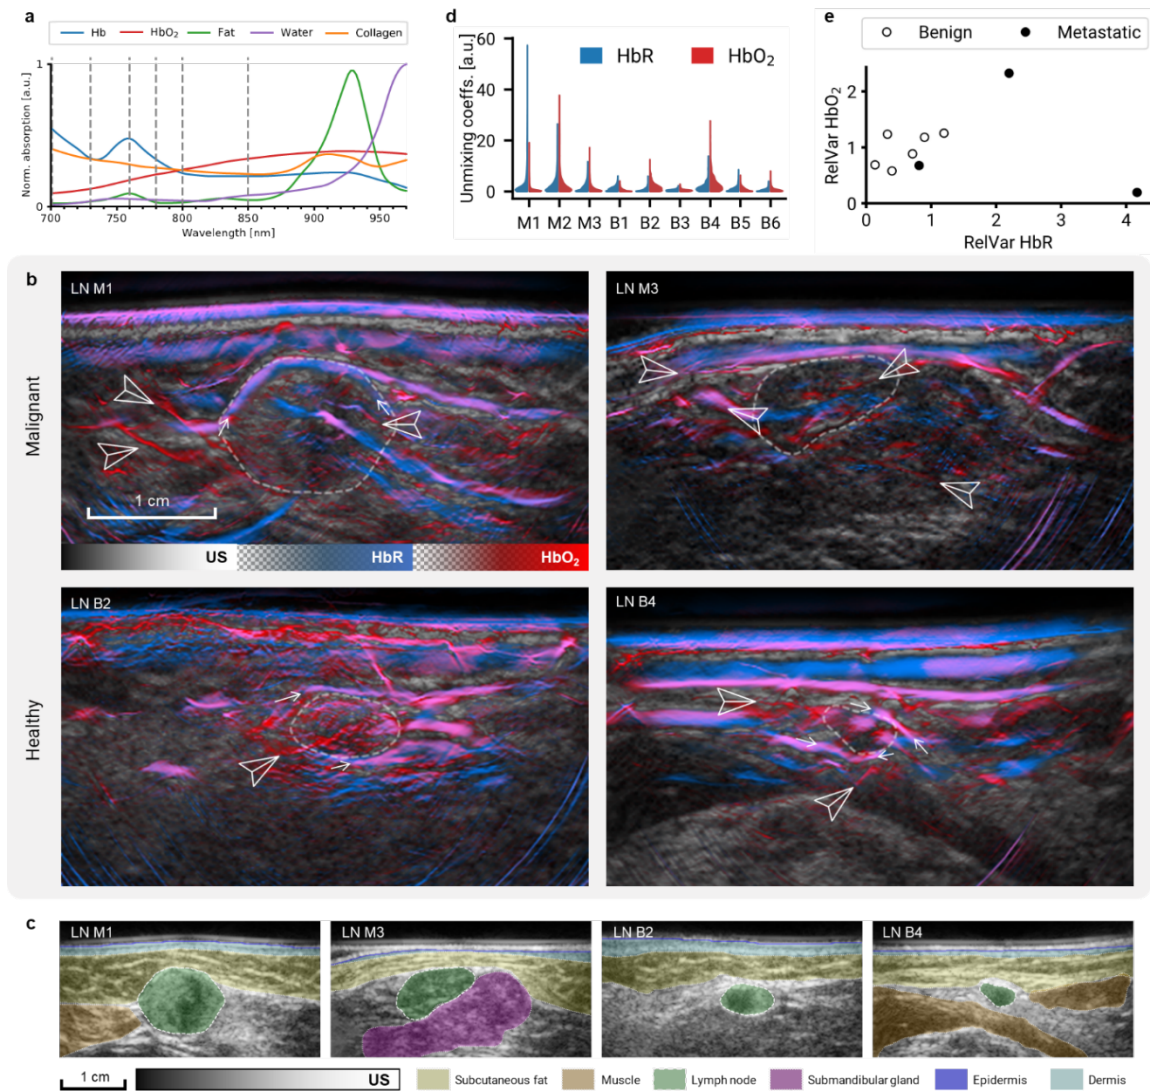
Intrinsic contrast in lymph nodes. a, Absorption spectra of main endogenous chromophores in the illumination range of the MSOT Acuity Echo scanner. Dashed lines denote the wavelengths used for the multispectral image acquisition (700, 730, 760, 780, 800, 850 nm). b, Ultrasound and linear spectral unmixing images of lymph nodes (LNs) M1, M3, B2, and B4. Arrowheads mark peripheral, feeding, and intranodal blood vessels. Small arrows mark signal enhancement around the LNs. Scalebar applies to all four images. Separate HbR and HbO₂ maps are provided in Fig. S4. Strong HbR signal in the epidermis can be attributed to the presence of melanin. c, Ultrasound images of the LNs displayed in (b) with localization of surrounding anatomical landmarks. d, Distribution of Hb and HbO₂ unmixing coefficients in three malignant LNs (M1-3) and six benign LNs (B1-6). e, Variance of chromophore concentrations in malignant and benign LNs relative to their 3 mm margins. Malignant LNs exhibit large increase of relative deoxy-hemoglobin variance. Abbreviations: LN M, malignant lymph node; LN B, benign LN; HbO₂, oxyhemoglobin; HbR, deoxyhemoglobin. Figure reproduced from *Vonk, Kukačka et al. "Multispectral optoacoustic tomography for in vivo detection of lymph node metastases in oral cancer patients using an EGFR-targeted contrast agent and intrinsic tissue contrast: A proof-of-concept study." Photoacoustics 26 (2022): 100362.*
